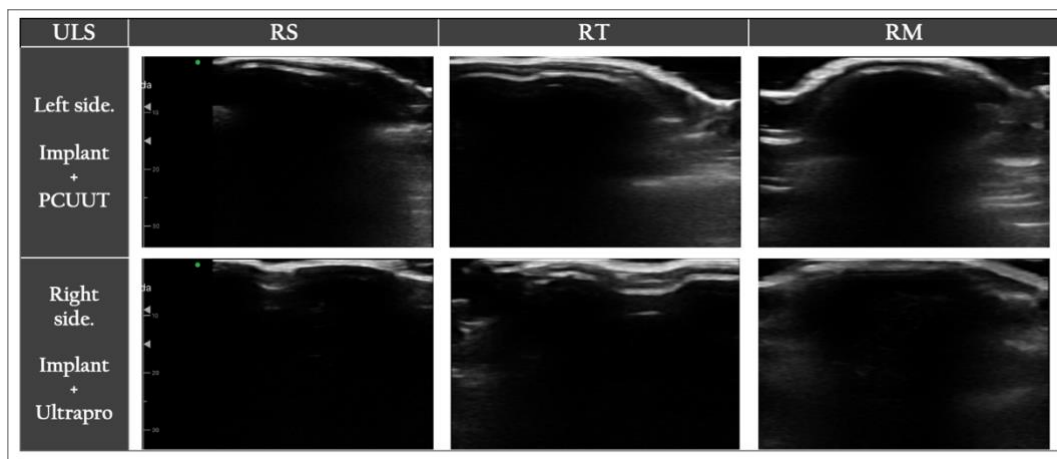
Ultrasound at 60 days. Dorsal images of Smooth, Texture, and Mesh control groups on the left (PCUUT mesh) and right side (Ultrapro mesh).
